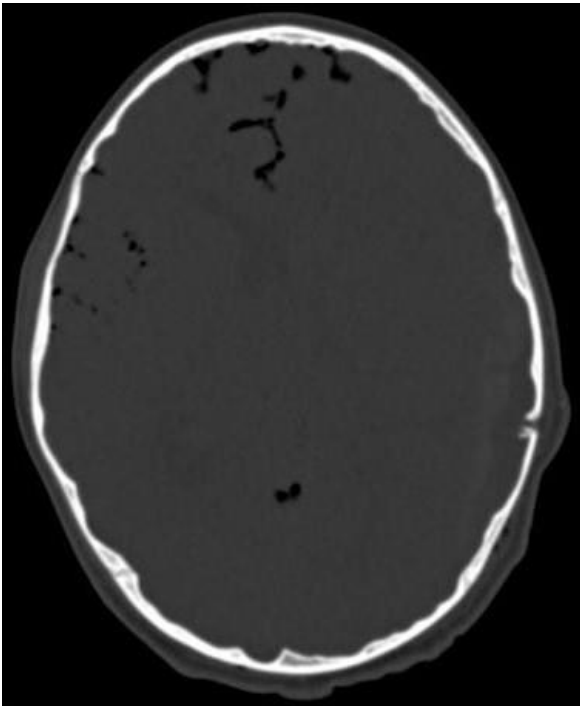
Post-operative CT-scan imaging showing complete epidural haematoma evacuation.
